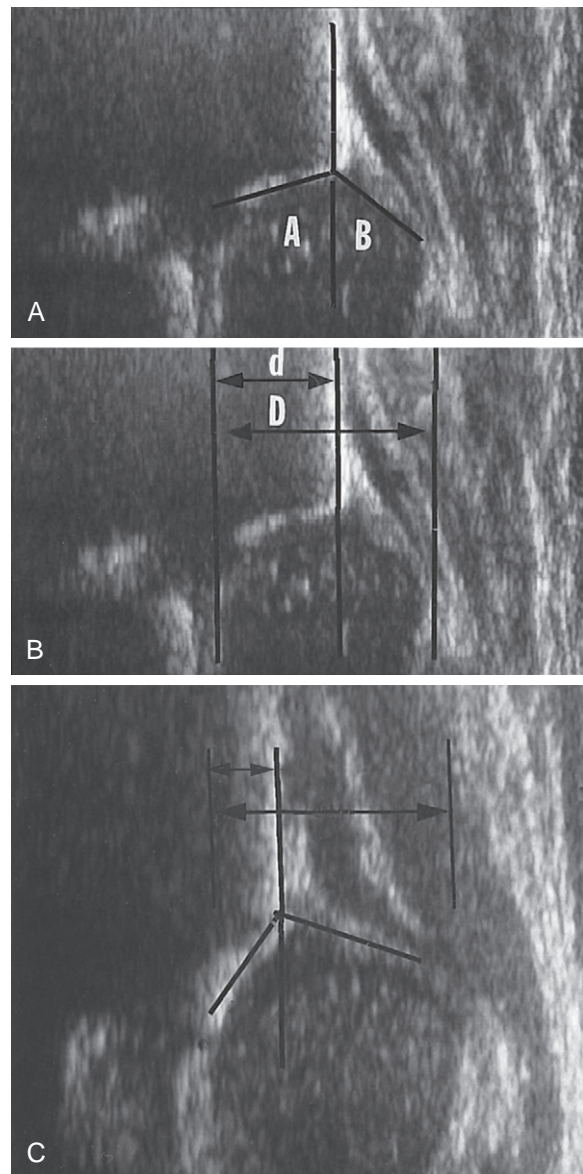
A, Standard coronal plane ultrasonogram of a normal infant's hip. The alpha angle (A) corresponds to the bony acetabular roof (normal, >60 degrees). The beta angle (B) represents the cartilaginous roof (normal, <50 degrees). B, Method for determining percent coverage of the femoral head: $d/D \times 100$ (normal, $\geq 50\%$). C, Coronal plane ultrasonogram of a dysplastic hip. The alpha angle was 40 degrees; the femoral head was subluxated with only 25% coverage.
